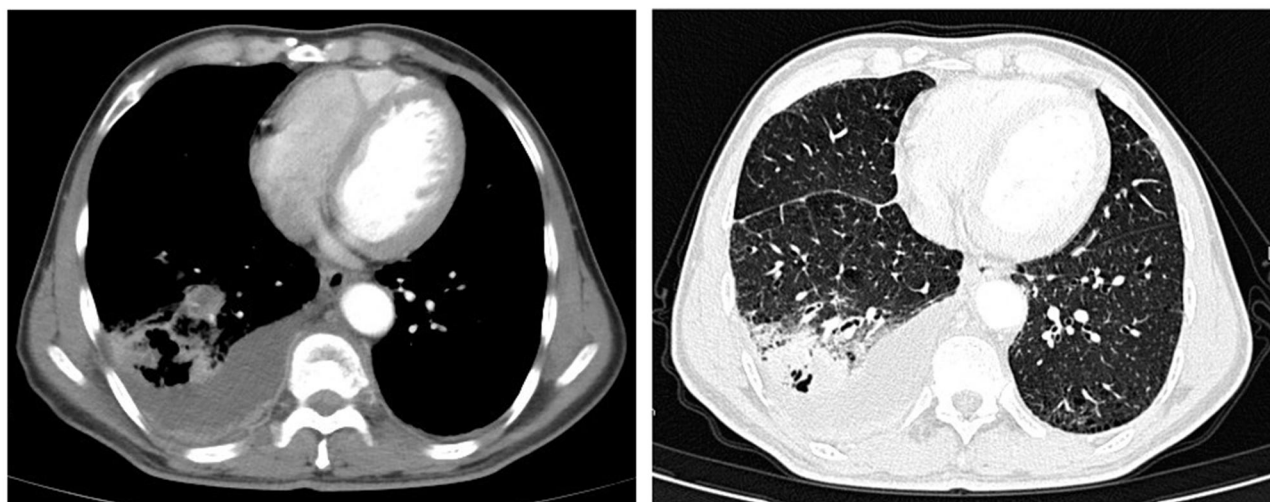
Chest CT at the time of the diagnosis.
